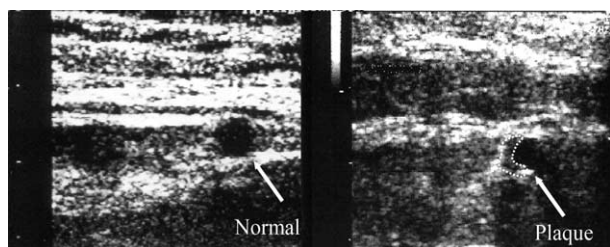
High-resolution echocardiographic short-axis imaging of a normal tract of the LAD, and a diseased tract, containing a partially calcified plaque, producing attenuation of the ultrasound beam.
